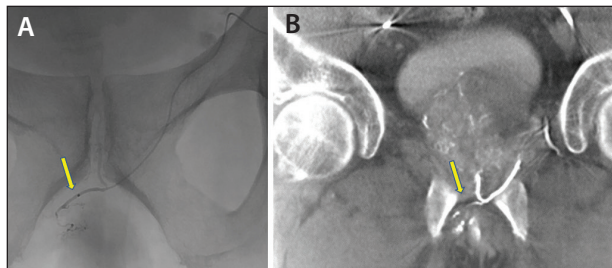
An unsubtract angiogram (A). Arterial enhanced cone-beam CT demonstrated small collateral branch (yellow arrow) to posterior right corpora and spongiosum (B).
